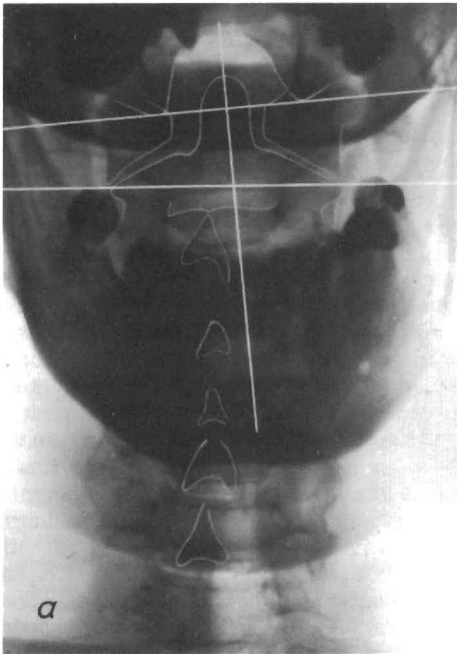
Anteroposterior X-ray of the cervical spine of a healthy subject, in neutral position, during active lateral flexion, and passive lateral flexion limited to the upper cervical region. (a) In neutral position the atlas is to the right in relation to the condyles, and the plane of the condyles and the axis converge on the right, the axis being rotated about 5 degrees to the left. (b) At active lateral flexion to the left the atlas is still to the right of the condyles and the plane of the condyles and the axis converge a little to the right, the axis now being rotated about 10 degrees to the left. (c) Passive lateral flexion of the upper cervical spine to the left: the atlas is now clearly to the left of the condyles and the plane of the condyles is parallel to the axis which is rotated about 10 degrees
